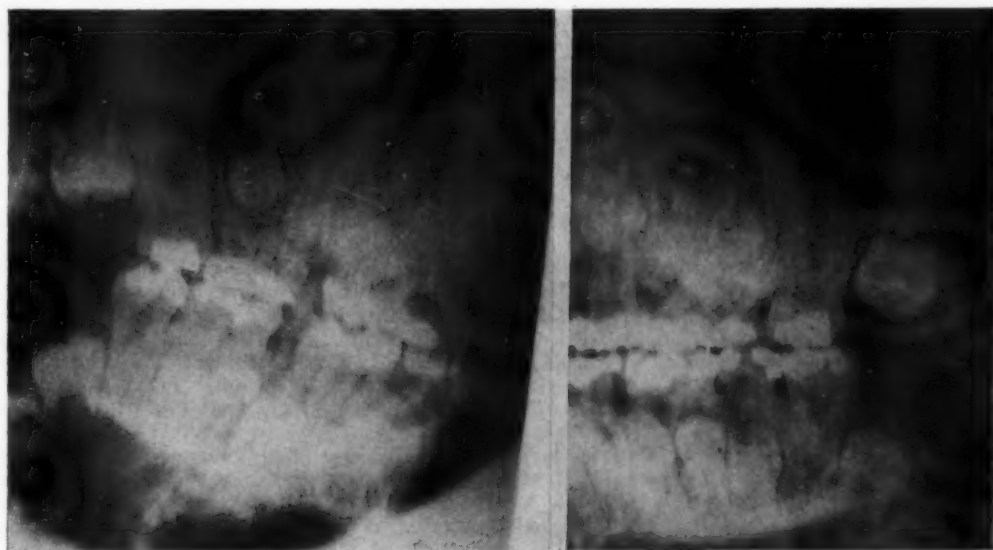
Lateral jaw roentgenograms of the patient in Fig. 7A. The permanent second molars and all the premolars are unerupted. Her dental age is 8 years, the same as her chronological age.
